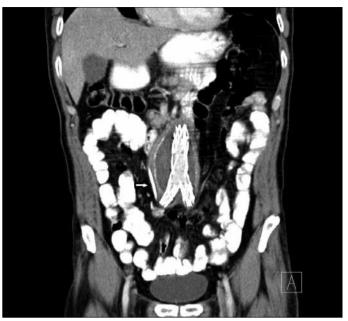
Postoperative coronal CT image: intra-aortic Y stent and right DJ catheter (white arrow)
